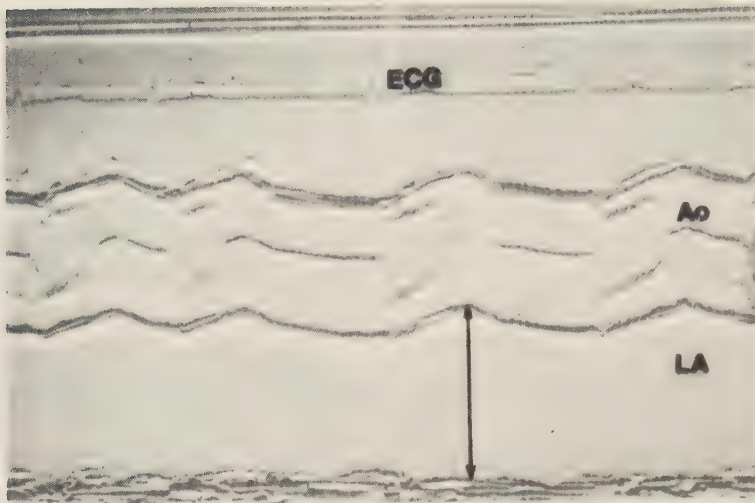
Echocardiogram of the aorta (Ao) and left atrium (LA) with measurement of left atrial dimension.
